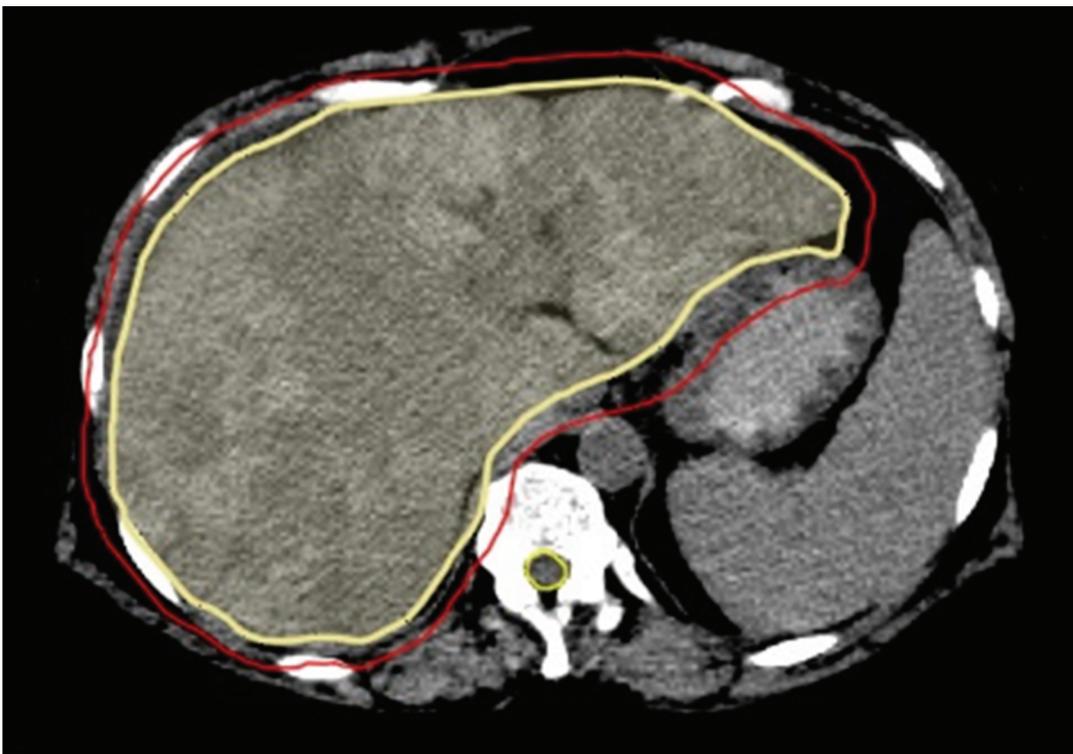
Axial computed tomography scan of abdomen indicating clinical target volume of liver and planning target volume contours prior to whole liver radiotherapy.
